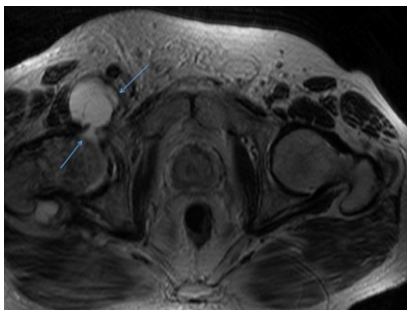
T1 weighted MR image of IB anterior to the hip joint. It shows a clear communication.
